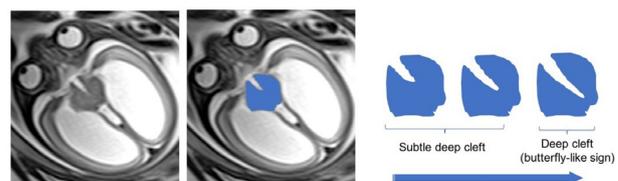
Demonstration of abnormal midbrain and cleft of a fetus in prenatal T2 MRI sequence. There is elongation of the midbrain and subtle depth of the midbrain cleft in the axial plane in keeping with type C DMJD (images A and B, midbrain highlighted in blue). Image C shows a visual reproduction of possible midbrain clefts and presumable depth variations in an axial plane, that are believed to coincide with the type of DMJD. Data from previous publications indicates that the pathognomonic butterfly-like sign with a deep cleft is not a constant finding for all DMJD types, most frequently described in type A; whilst subtle deep cleft has been inconsistently reported in thalamus-midbrain continuity (types B and C).
